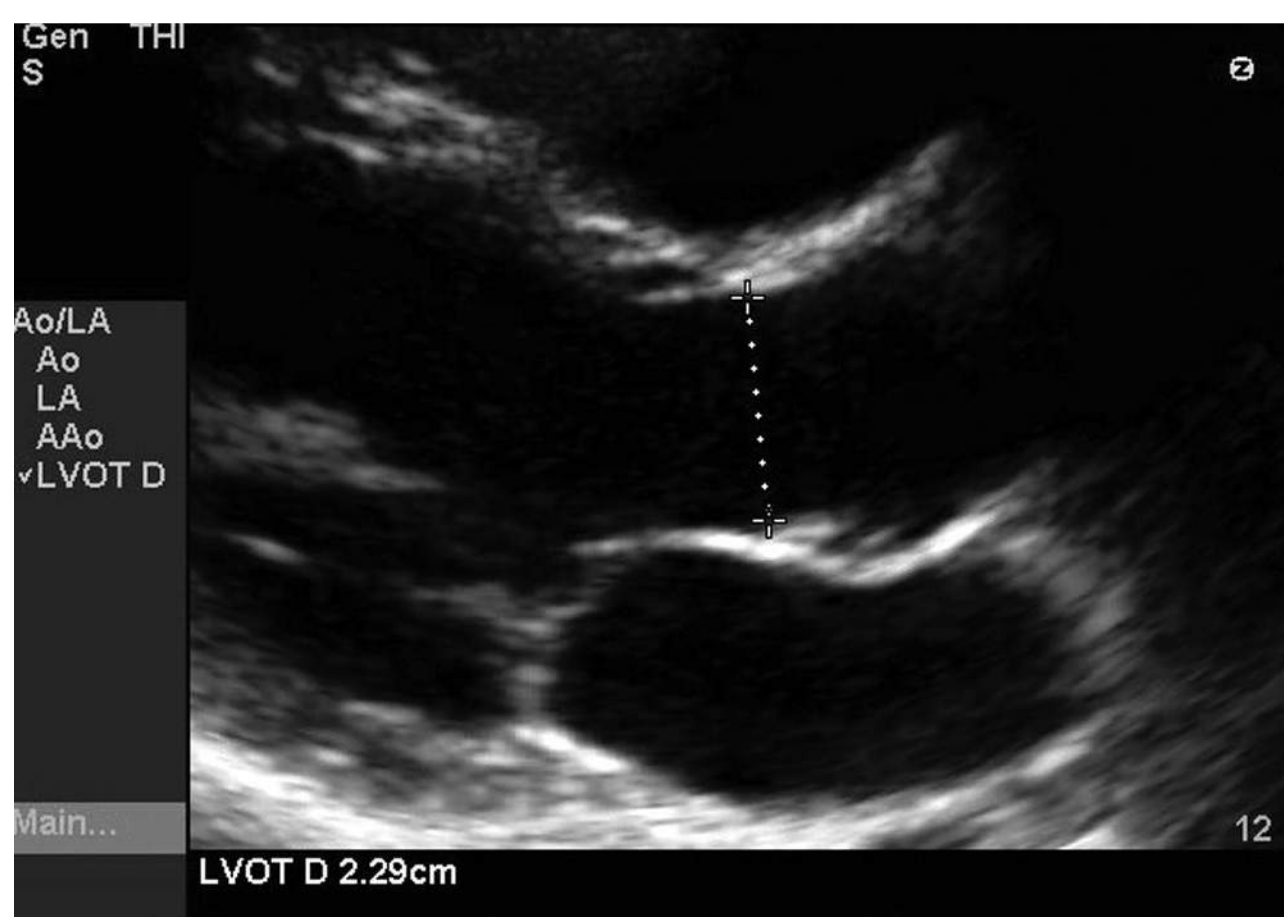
Parasternal long-axis view demonstrating correct measurement of left ventricular (LV) outflow tract diameter at the aortic valve leaflet point of attachment. The US system will use this measurement to calculate LV outflow tract area.
